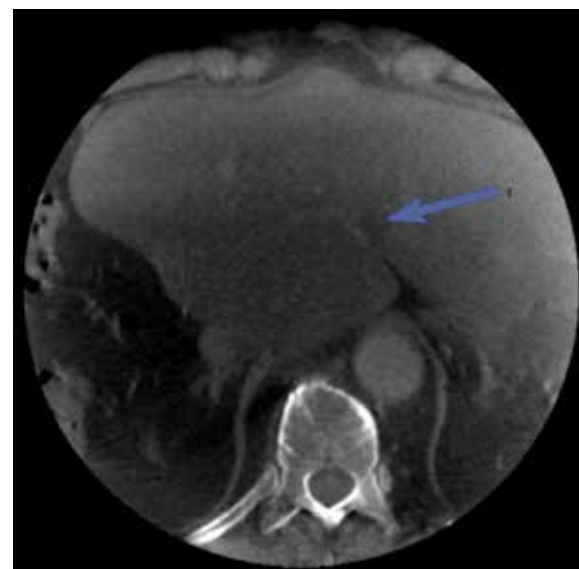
Identification of the lesion on the CBCT (70 sec delay and 80cc of contrast media).
